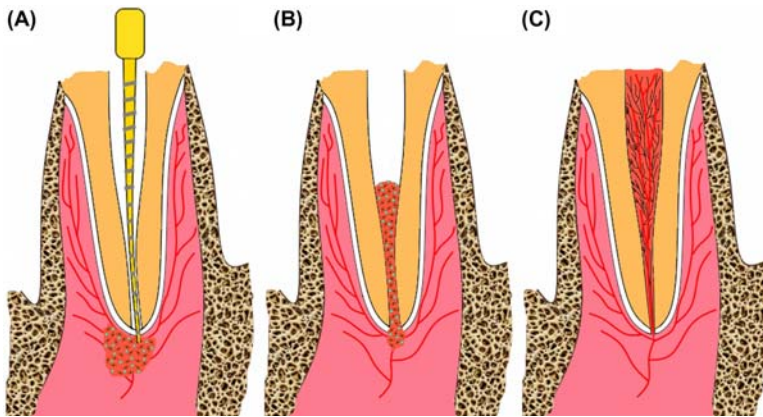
Biological basis of regenerative therapy. (A) Blood clot is initiated from the periapical area, (B) blood clot and pluripotent cell population enter the root canal, (C) the growth of pulp-like connective tissue becomes evident inside the root canal.
